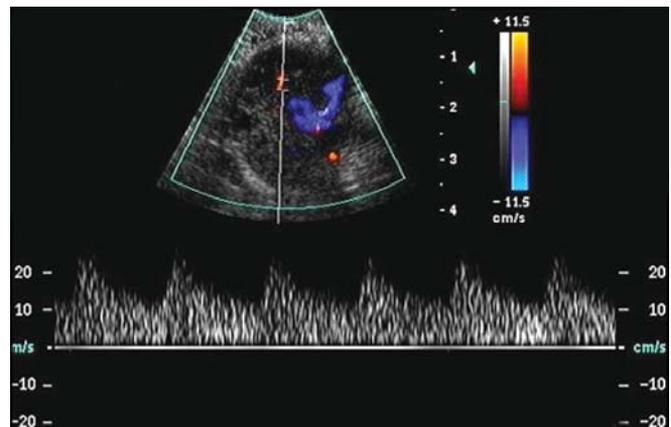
Color and pulsed Doppler of ovarian blood flow
